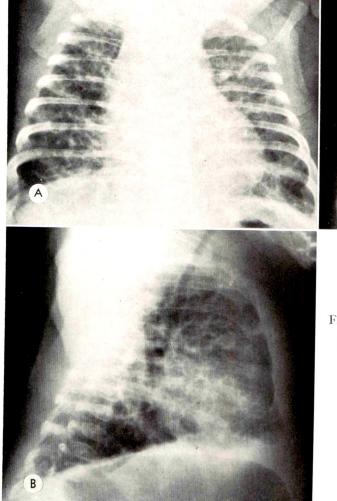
Case II. Chest roentgenogram obtained at 15 days of age shows diffuse reticular infiltrates producing a "bubbly" appearance.
